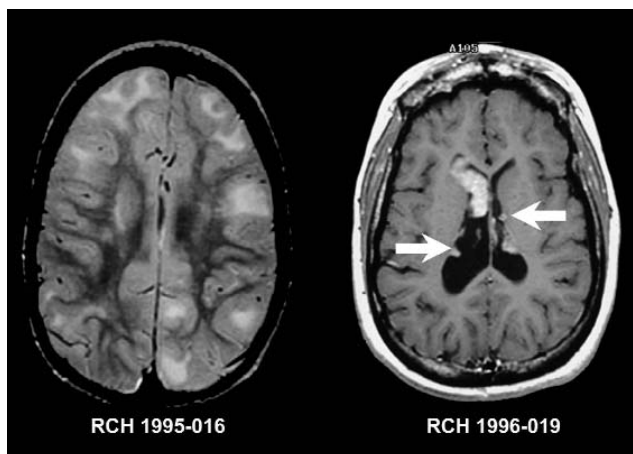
Imaging features of tuberous sclerosis. Axial T2-weighted MRI (left) and contrast-enhanced axial T1-weighted MRI (right). The image on the left shows multiple focal areas of broadened gyri, blurring of the gray-white junction and increased signal in the subcortical white matter typical of cortical tubers. The image on the right shows multiple subependymal nodules (arrows) consistent with subependymal hamartoma and a large enhancing lesion at the right foramen of Monro consistent with a giant cell astrocytoma. MRI, magnetic resonance imaging
